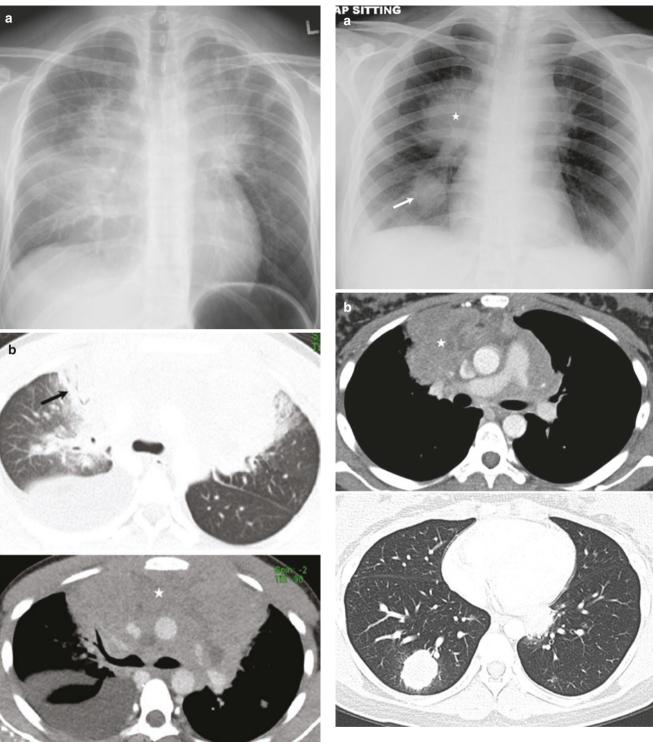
A 59-year-old man with lymphoma. (a) Frontal radiograph of chest shows mediastinal widening with areas of consolidation in perihilar region. (b) Contrast-enhanced axial CT image in lung and soft tissue window shows areas of consolidation in upper lobes (arrow) with right pleural effusion and confluent mediastinal lymphadenopathy (asterisk) encasing mediastinal vessels
